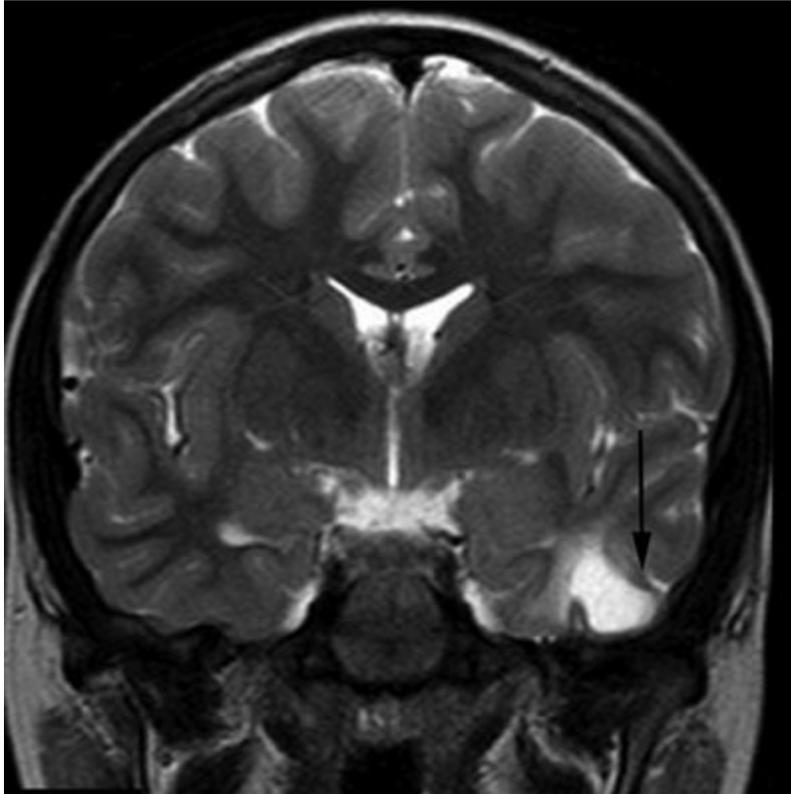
Ganglioglioma. Coronal T2-weighted image from MRI without gadolinium in a 9-year-old boy with a 6-year history of seizures consisting of staring spells shows a cystic cortical lesion of the left inferior temporal gyrus (arrow).
